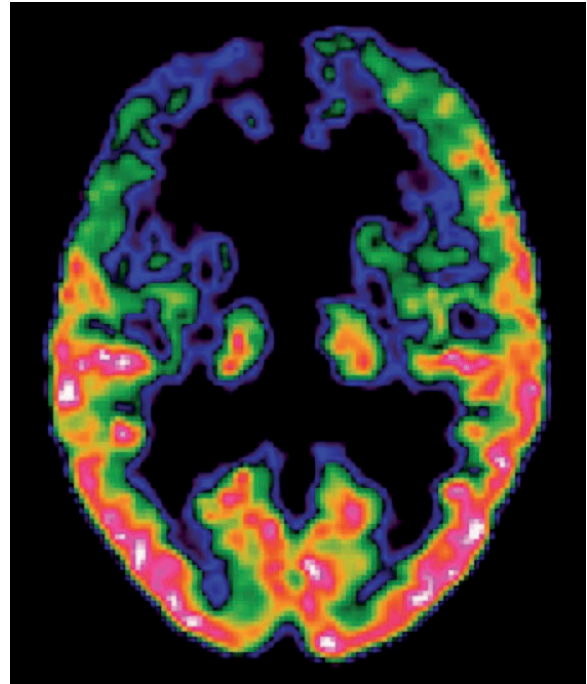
$^{18}\text{F}$ -FDG PET findings in a patient with FLD
